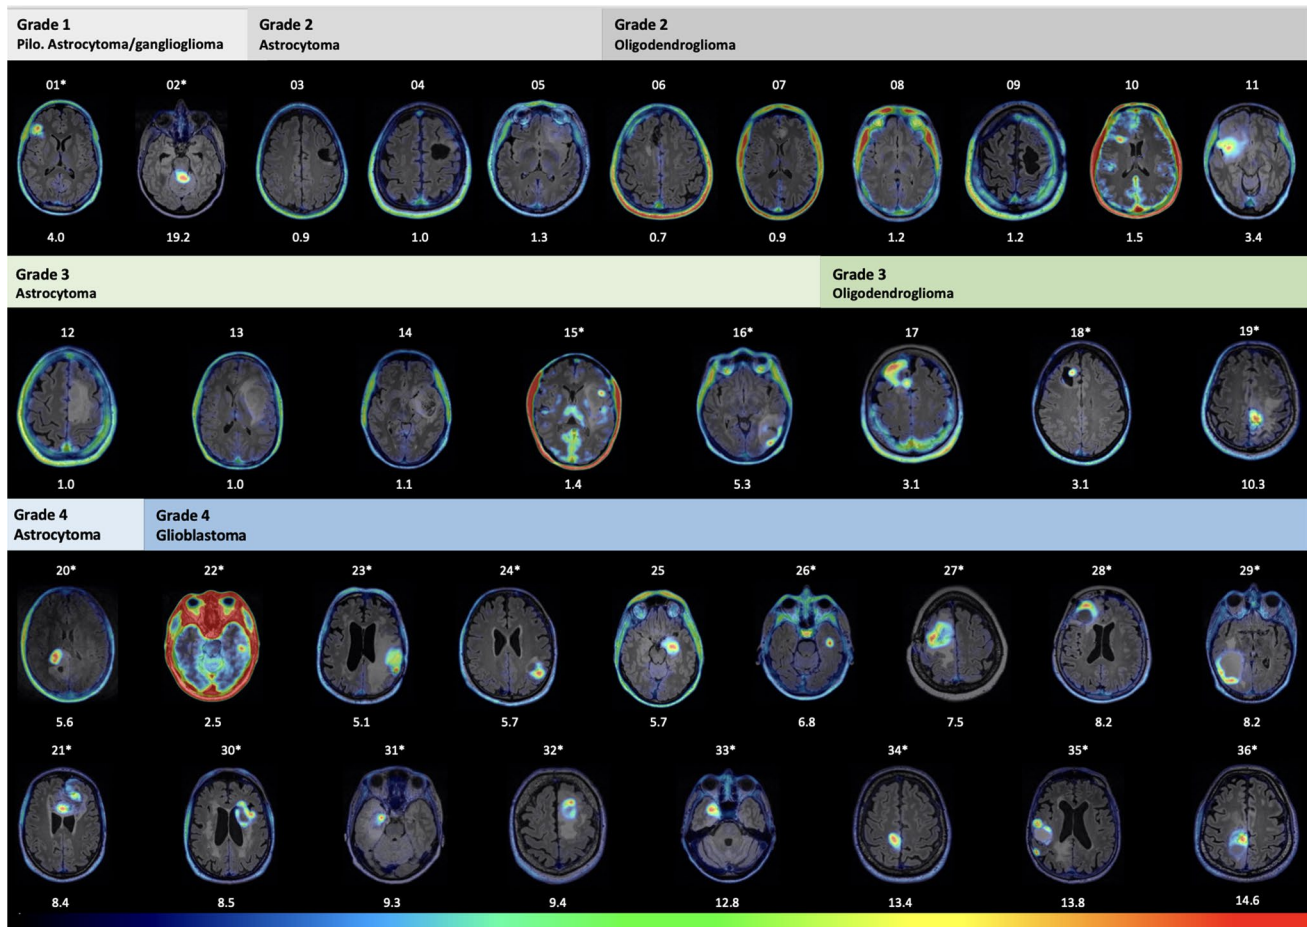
PET/MR images from all patients sorted by glioma grade and type. Patient ID (from 01 to 36) is shown above — and TBR_{peak} below each image. PET color scale: $SUV_{background}$ to SUV_{max} for PET
